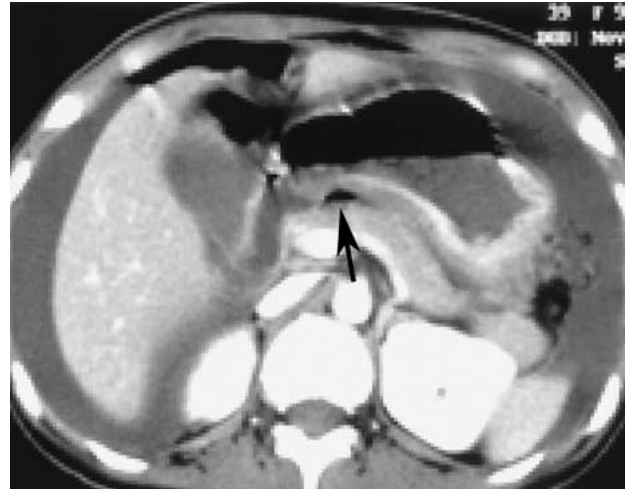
Contrast-enhanced CT image in a patient with gastric perforation. Air in the lesser sac is visible (*arrow*). Large amounts of ascites and free air in the anterior peritoneal surface of the liver are demonstrated.
